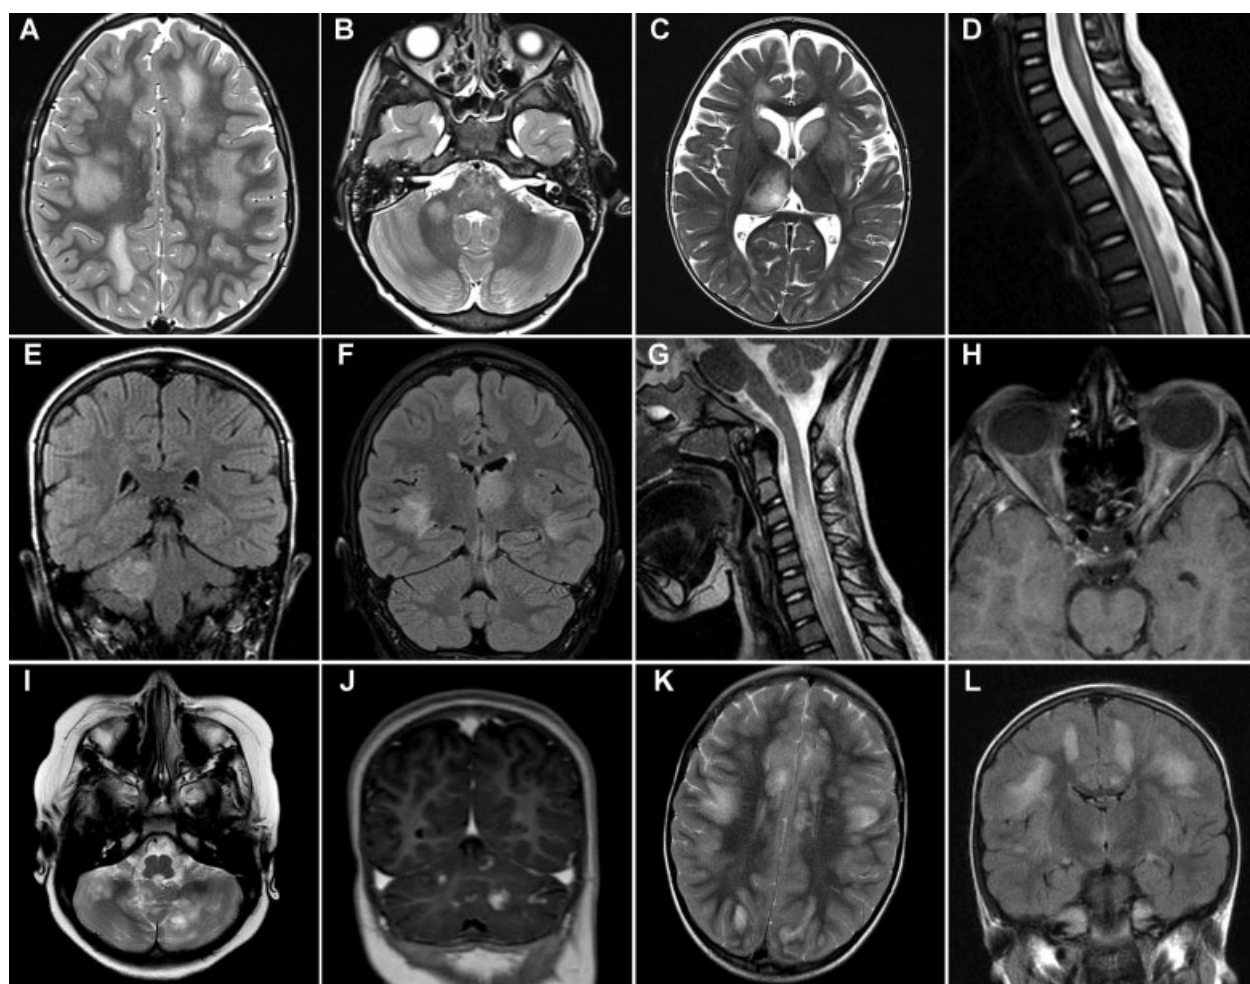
Children with ADEM and MOG-abs usually show an MRI with fluffy, poorly-demarcated bilateral lesions and a widespread distribution of lesions. The spinal cord is often affected with lesions spanning more than three segments. (A, B) (axial-T2) Cerebral MRI of a 7-year-old boy with MOG-ab seropositive ADEM showing widespread poorly-demarcated lesions. (C, D) Cerebral and spinal MRI (axial-T2, sagittal-T2) of a 1-year-old boy with MOG-ab seropositive ADEM showing prominent involvement of thalamus and basal ganglia and spinal lesions spanning more than three segments (LETM). (E, F) Cerebral MRI (coronar-FLAIR) of a 5-year-old boy with MOG-ab seropositive MDEM showing a cerebellar lesion in the third episode (39 months after first episode) and new deep gray matter, cortical and juxtacortical white matter lesions in the fourth episode (87 months after first episode). (G) Spinal MRI (sagittal-T2) of a 5-year-old girl showing a MOG-ab seropositive LETM. (H) Cerebral MRI (Gd-enhanced axial-T1) of a 12-year-old boy with unilateral MOG-ab seropositive ON. (I, J) Cerebral MRI (axial-T2, Gd-enhanced coronar-T1) of a 4-year-old girl with MOG-ab seropositive MDEM showing in the sixth episode atypical features with ring enhancing cerebellar lesions. (K, L) Cerebral MRI (axial-T2, coronar-FLAIR) of a 5-year-old girl with ADEM and widespread large lesions but without MOG-abs suggesting that other autoantibodies are instrumental in the disease process. MOG, myelin oligodendrocyte glycoprotein; MRI, magnetic resonance imaging.
